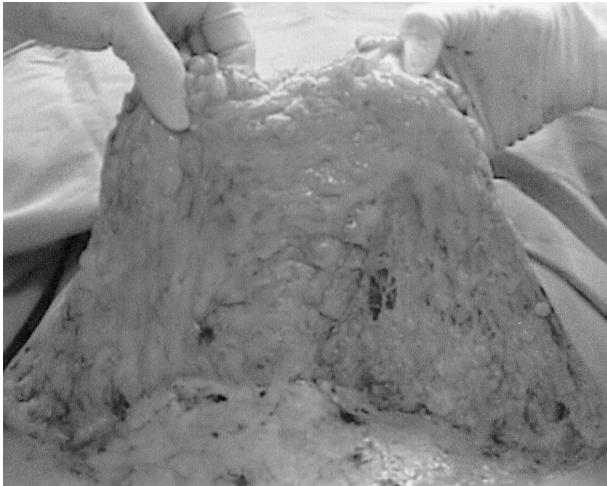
Flap lifted during the abdominoplasty for evaluation of the structures where internal ultrasound (left side) and the tumescent technique (right side) were used.
